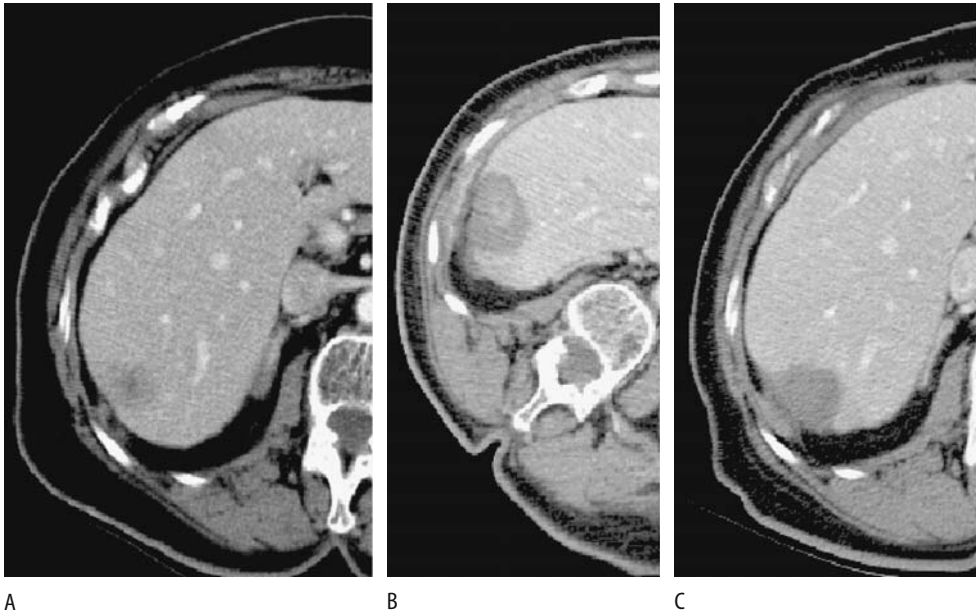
Radiofrequency ablation of metastatic colon carcinoma. Transverse CT images pretherapy (A), immediately posttherapy (B), and 4 months later (C) show progression of changes. No enhancement was evident within the lesion. (Courtesy of Fred T. Lee, M.D., University of Wisconsin.)
